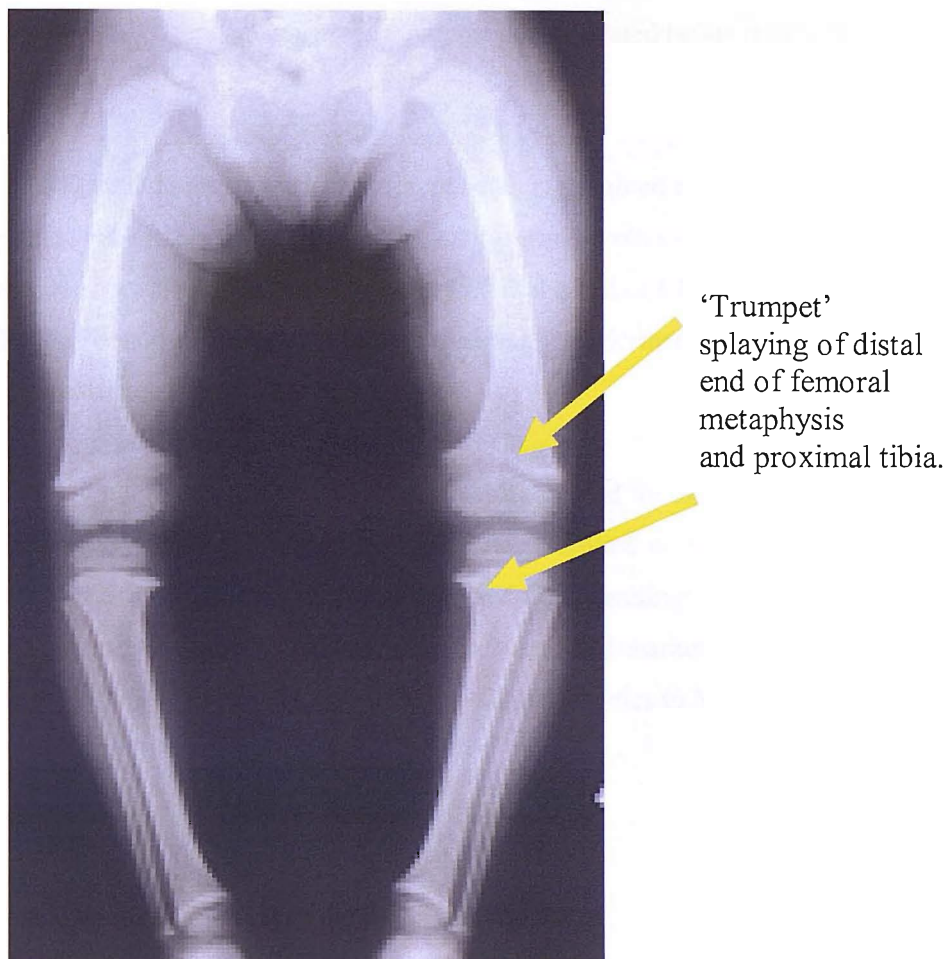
Radiograph of a 2 year old with rickets (vitamin D deficiency). Note the 'trumpet-like' ends of the shafts of the long bones particularly in the femora and tibiae.
